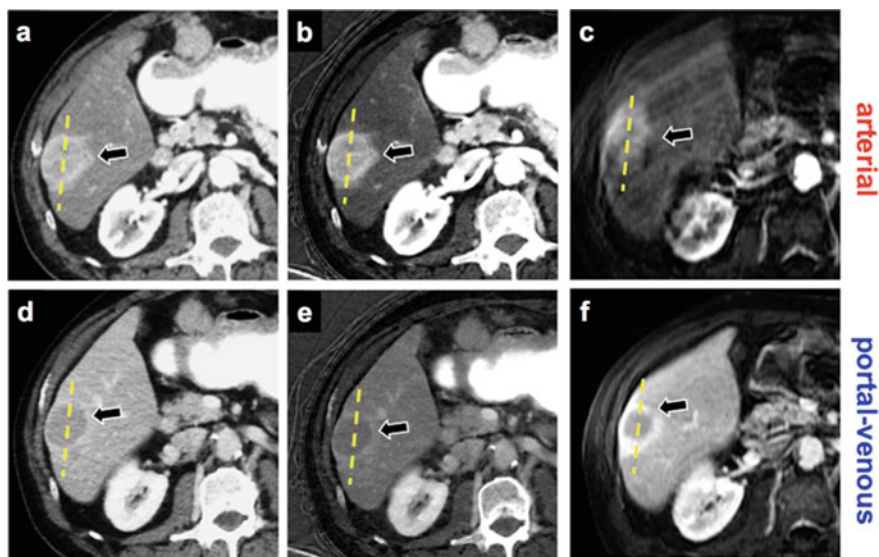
Axial DECT and MR images of a 72-year-old male patient with hepatocellular carcinoma (HCC) in segment VI. a–c Arterial phase. d–f Portal venous phase. a, d Virtual Mono-Energetic (VME) CT image (65 keV). b, e Quantitative Iodine Material Density (IMD) CT image. c, f MR image of the same patient. In (b, e) one observes an increased contrast between HCC and non-tumour liver. Adapted from Pfeiffer D. et al. [27]
